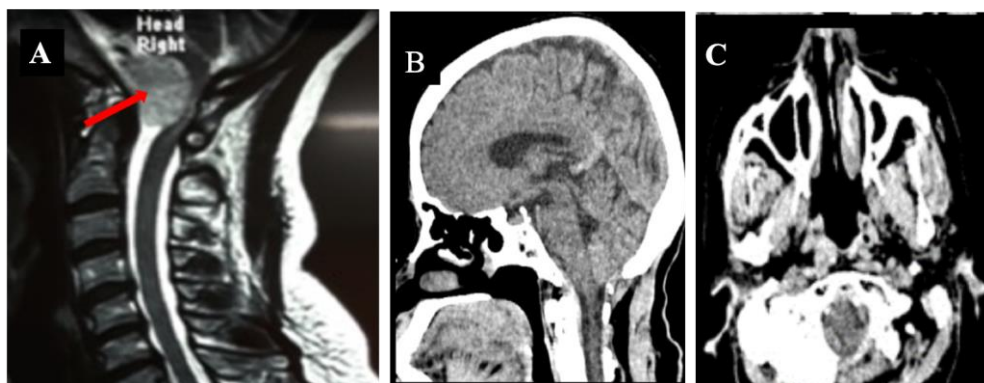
Preoperative MRI imaging of patient 3 reveals an anterior intradural extramedullary tumor (red arrow on A), and the control CT scan (B and C) confirms full excision.
